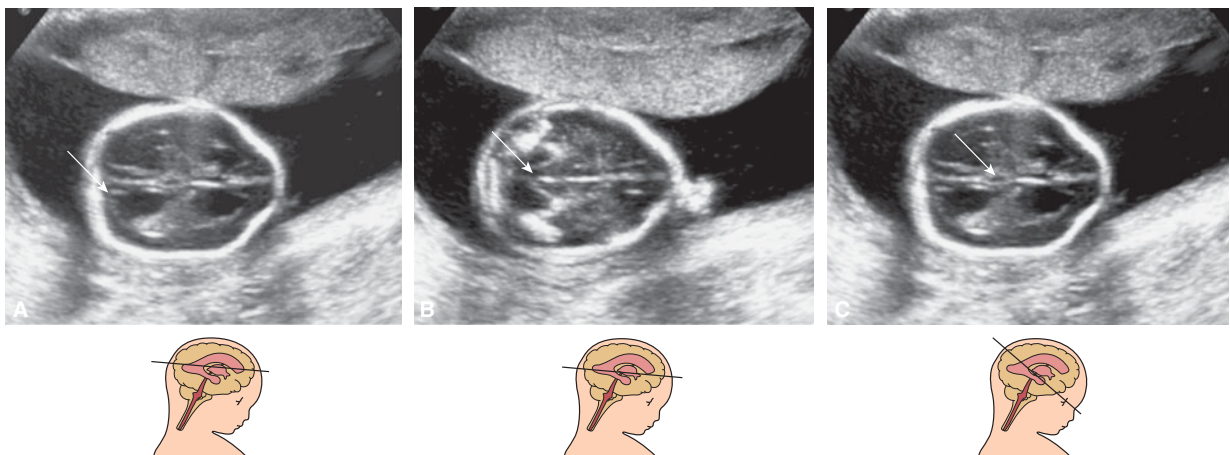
Additional sonographic findings seen by transabdominal sonography that help make the diagnosis of Chiari II malformation. (A) “Ventricular point” (*arrow*) a pointed deformity of the posterior horn. (B) “Tectal beaking” (*arrow*), the tectum is abnormally elongated as the result of the spinal defect. (C) Interhemispheric cyst (*arrow*).
